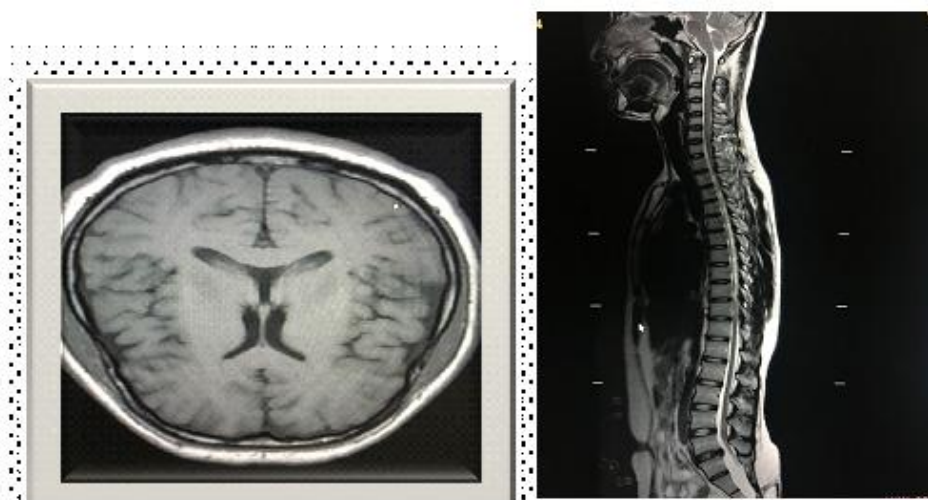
Normal MRI Brain with Spine Screening
